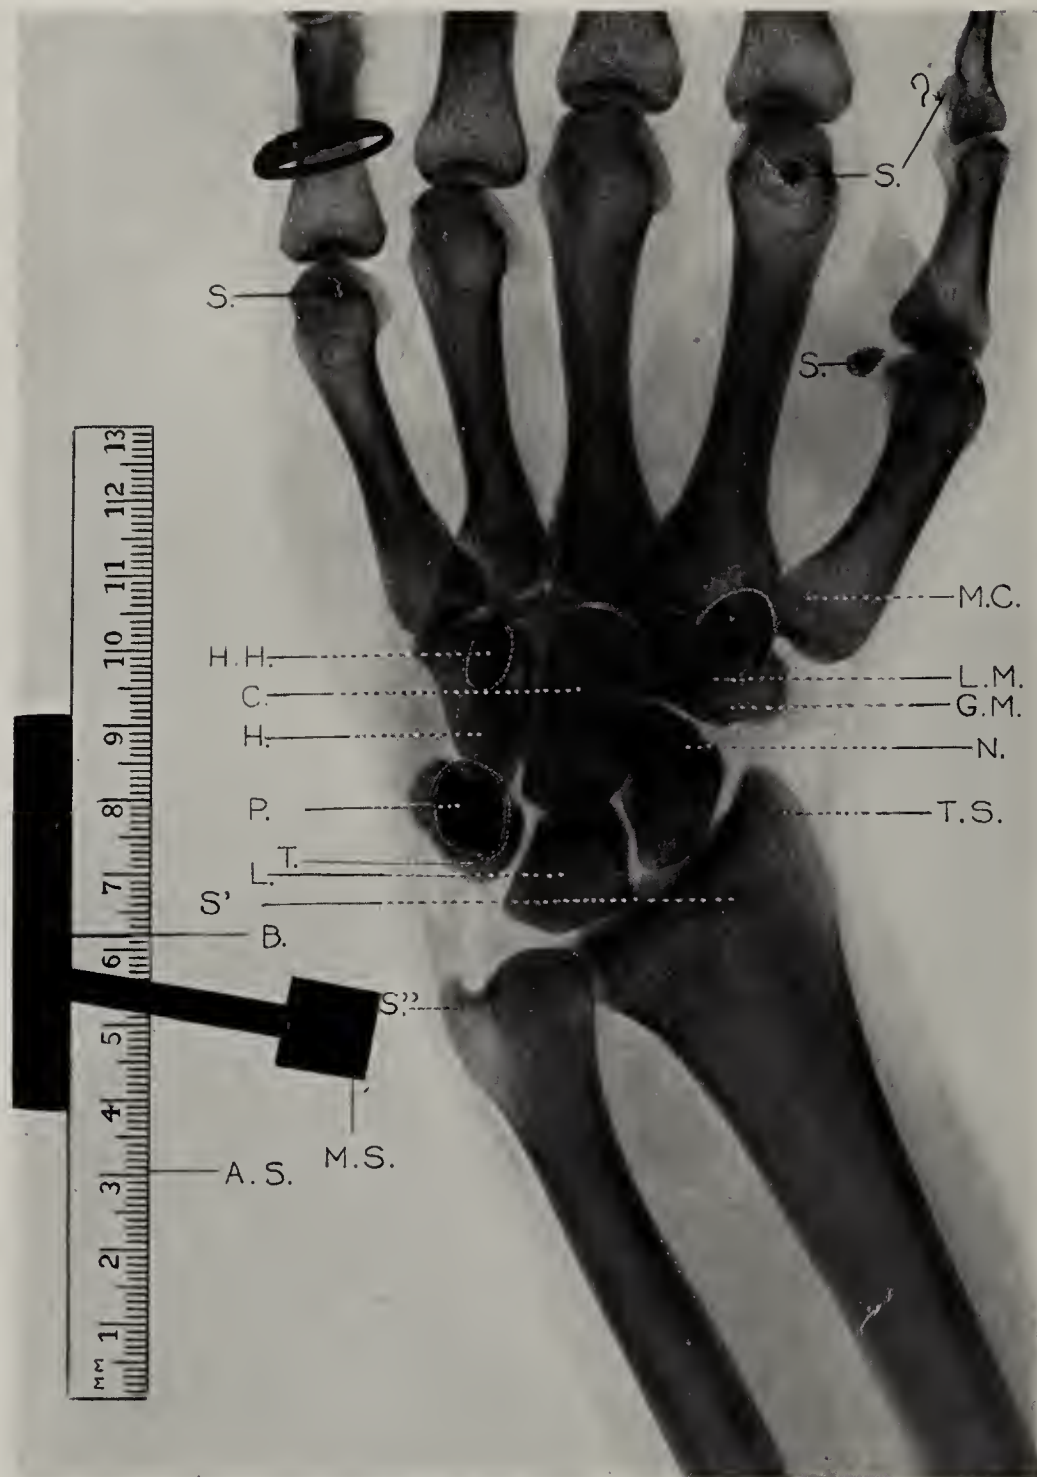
Normal hand with measuring device in position to determine distance of pisiform from styloid of the ulna. The hand is slightly to radial side. The steel marker is, of course, parallel with the plate surface and 3.75 cm. above plate at a level with the styloid. The target distance is 65 cm. Many plates at different time limits and target distances were made. This instrument, with the ever constant millimeter scale and the use of calipers, corrects in all directions shadows on the plate due to divergence of the X-rays. The position of the pisiform is of especial importance in prognosis in Colles' fractures or other wrist injuries, and it was the necessity for accurate measurements here that demanded a device similar to the one herein described. The letters on the figure beginning at the distal part of the hand are: S, sesamoid bones; L. M., lesser multangular; G. M., greater multangular; H, hammate; H. H., hook on hammate; C, capitate; P, pisiform; N, navicular; M. S., metal measuring plate; T, triquetral; L, lunate; S', styloid of radius; S'', styloid of ulna; A. S., aluminum scale; B, brass standard; M. C., metacarpal; T. S., tip of styloid of ulna. This photograph of a "soft tissue" plate has not been retouched except to reproduce what appears in the original plate.
